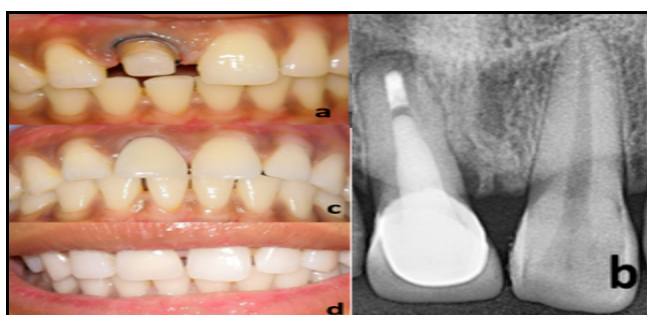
a) Tooth preparation photograph, b) Crown cementation radiograph, c) Crown cementation photograph, d) Follow up photo graph
